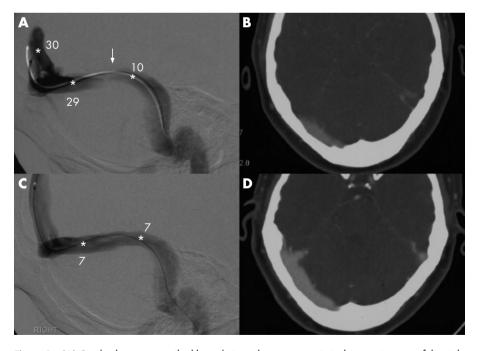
(A) Cerebral venogram, tilted lateral view, shows a stenosis in the anterior part of the right transverse sinus (arrow). Numbers denote pressure (mm Hg) at each asterisk. (B) CT venogram axial source image shows a generally narrow right transverse sinus with a stenosis anteriorly. (C) Cerebral venogram after lumbar puncture (LP) shows resolution of the right transverse sinus stenosis and no pressure gradient. (D) CT venogram 1 h after LP confirms the right transverse sinus stenosis has resolved, with a general increase in sinus calibre. The left transverse sinus is not in the plane of section but responded similarly.
